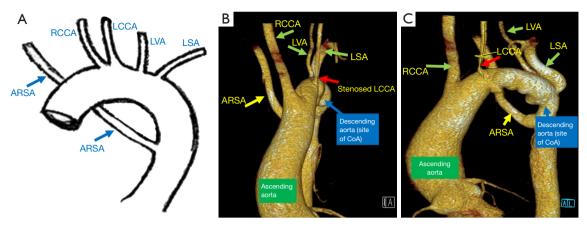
Configuration of the aortic arch identified in the patient. (A) Scheme of the aortic arch branching in the patient. In this configuration, the brachiocephalic trunk is absent. The RCCA arises as the first vessel from the aortic arch, followed by LCCA, LVA, LSA and ARSA. (B,C) Patient's CTA images. Site of the operated CoA (blue arrow). The sequence of the aortic arch branching is as follows: RCCA, LCCA which is stenosed (red arrow), LVA, LSA, and finally ARSA indenting the esophagus posteriorly. RCCA, right common carotid artery; LCCA, left common carotid artery stenosis; LVA, left vertebral artery; LSA, left subclavian artery; ARSA, aberrant right subclavian artery; CoA, coarctation of the aorta; CTA, computed tomography angiography.
